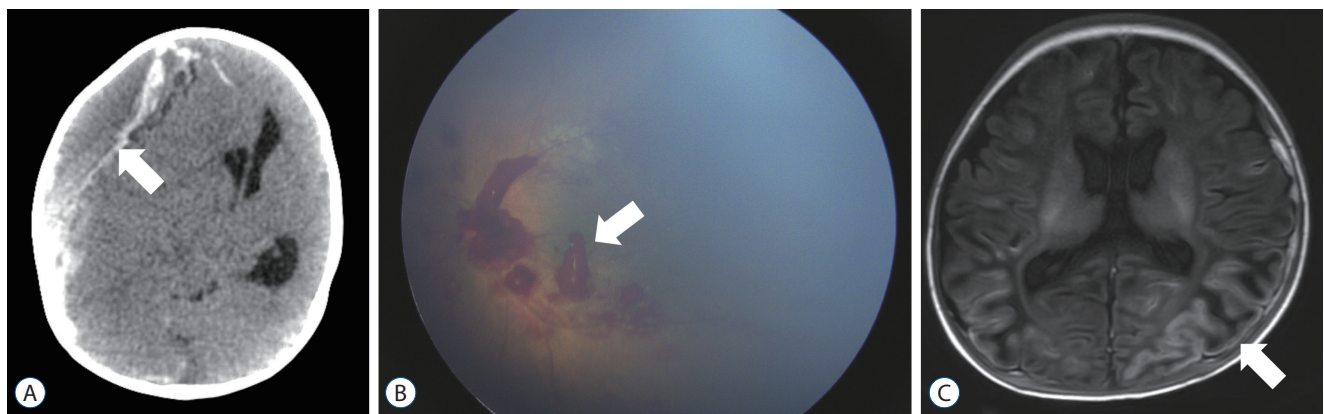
Triad of abusive head trauma. A : Subdural hematoma, computed tomography axial scan. B : Retinal hemorrhages, disc photography in the left eye. C : Encephalopathy, T2-weighted axial magnetic resonance image. Each lesion is marked with an arrow.
